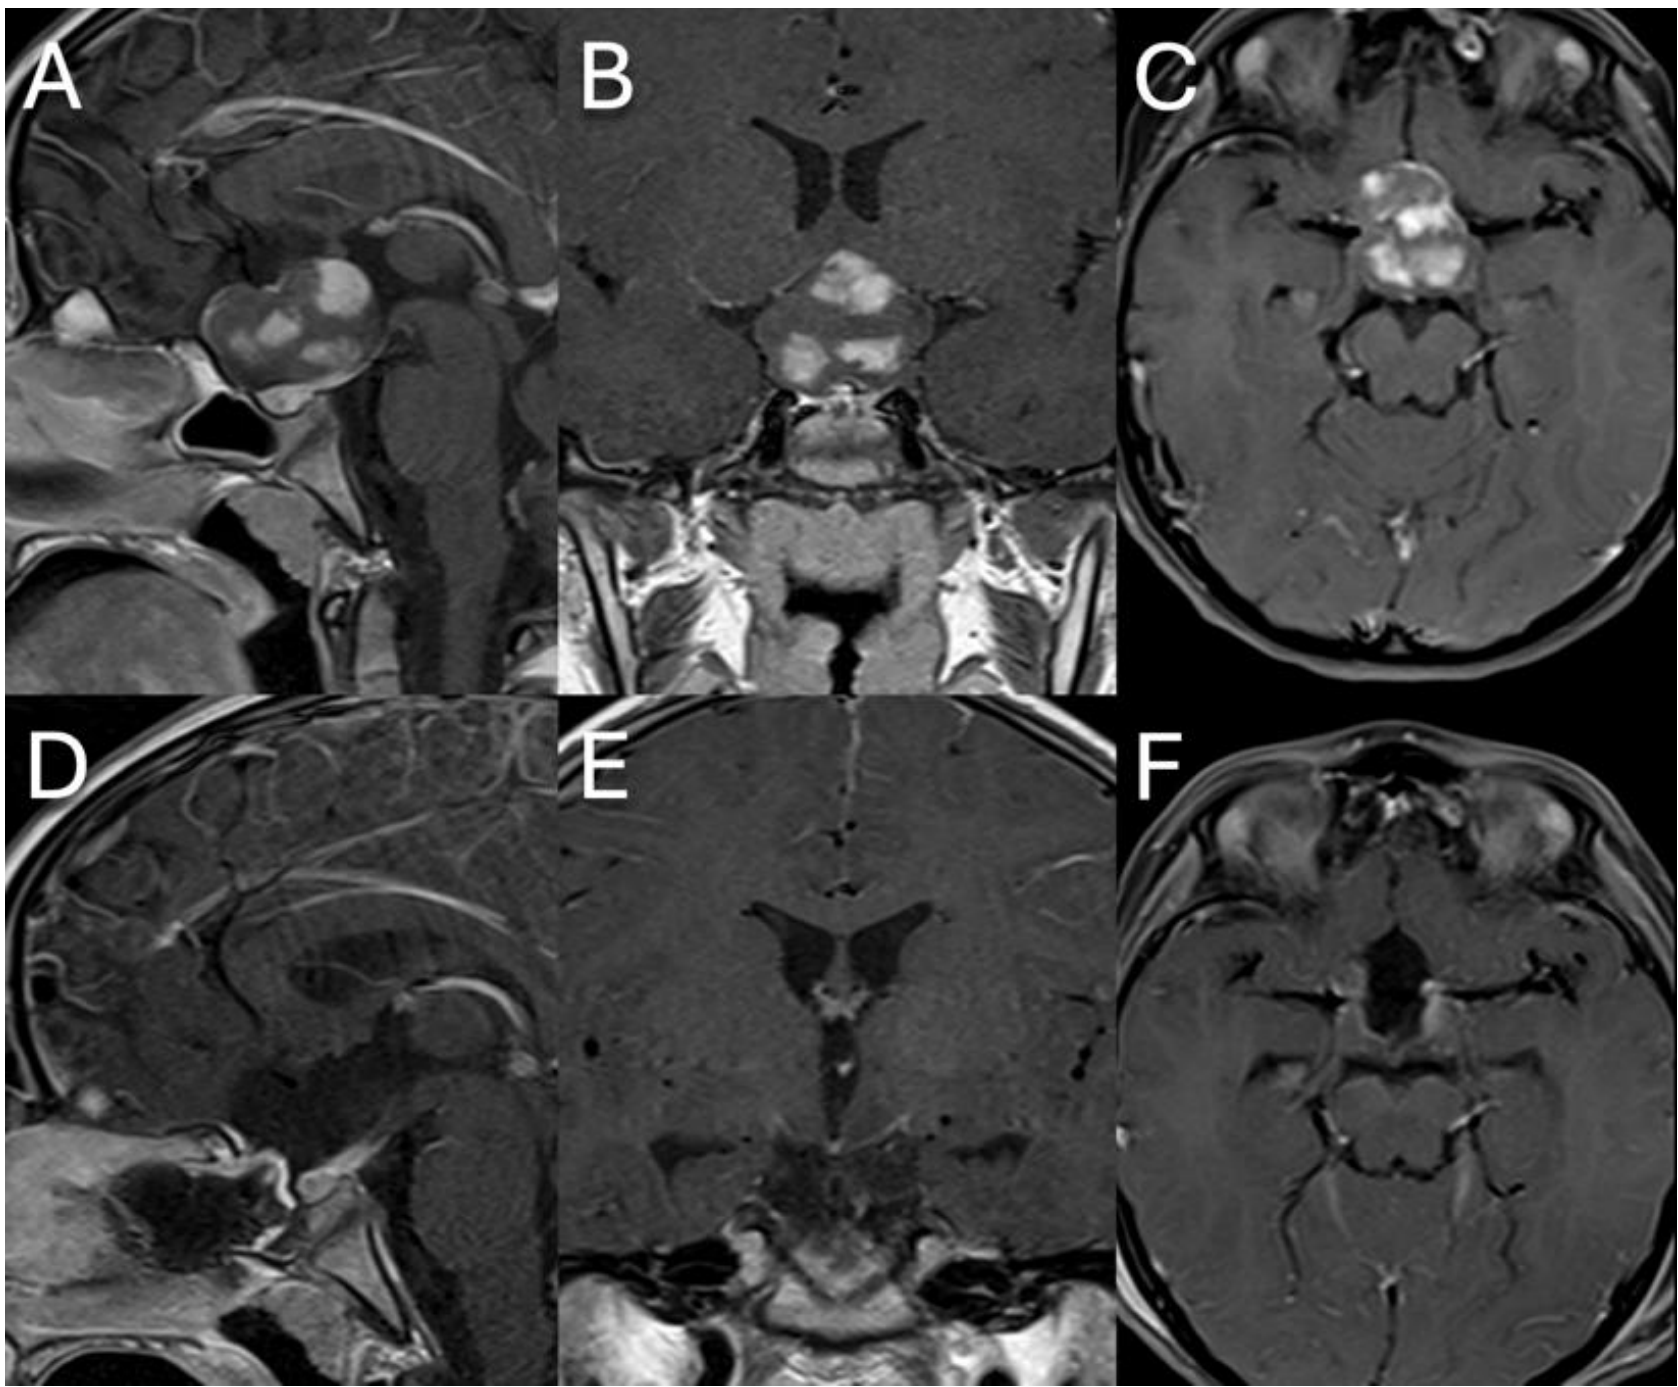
Pre- and postoperative MRI. (A) Sagittal, (B) coronal, and (C) axial preoperative enhanced images of the sella demonstrating a lobulated tumor extending into the sellar and suprasellar regions with heterogeneous enhancement, measuring 27 x 27 x 30 cm. In the sagittal view, there is a posterior displacement of the pituitary stalk, inferior compression of the pituitary gland, and extension to the floor of the third ventricle (C) Sagittal, (D) coronal, and (F) axial postoperative enhanced imaging showing a safe near-total resection of the tumor, while preserving structurally the hypothalamus bilaterally, as well as the pituitary gland and the infundibulum.
